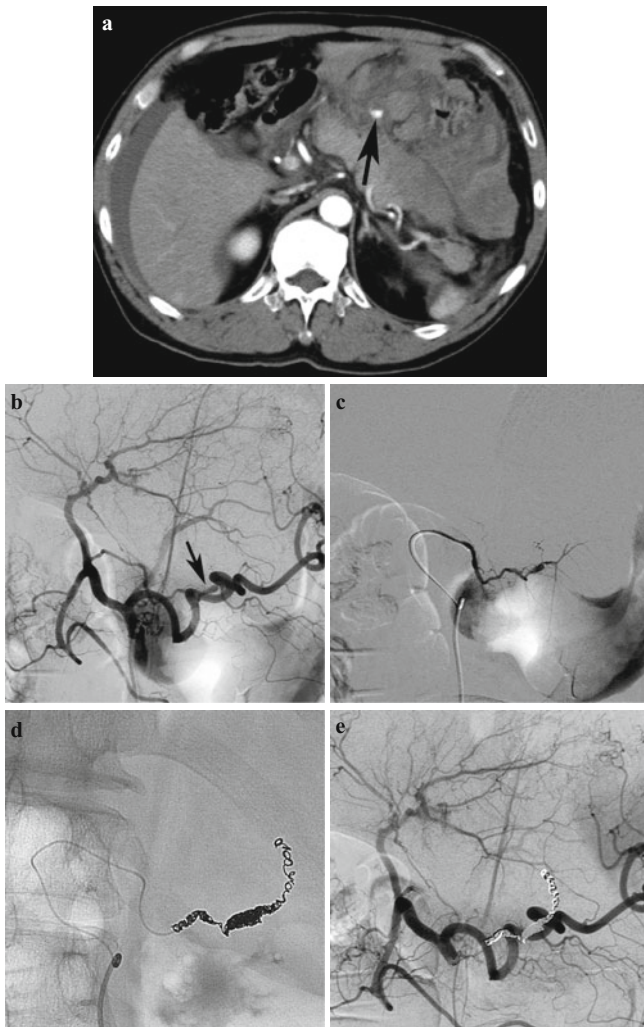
A 54-year-old man had spontaneous rupture of the right gastric artery. a Arterial phase computed tomography (CT) shows intraperitoneal hemorrhage and extravasation of contrast material from the right gastric artery (arrow). b Celiac arteriography shows the tortuous right gastric artery with aneurysmal dilatation (arrow). c Arteriography of the right gastric artery raises a suspicion of segmental arterial mediolysis. d Right gastric artery was embolized using 32 Tornado Coils through a 1.8F tip microcatheter. e Celiac arteriography after microcoil embolization shows occlusion of the right gastric artery. Hemostasis was obtained with the procedure
